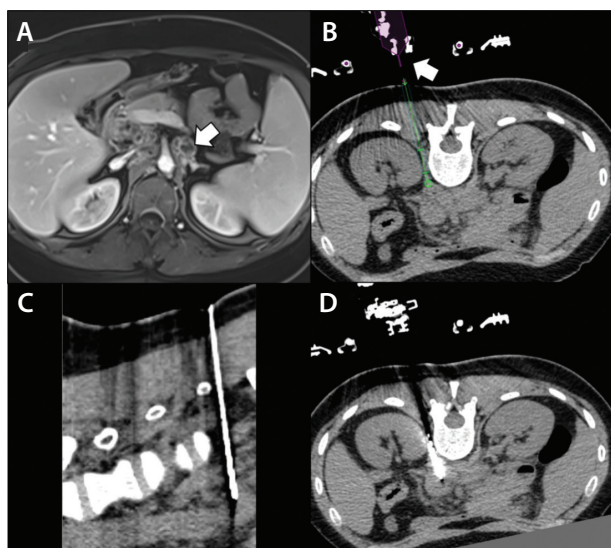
A CT-guided biopsy was performed using the Xact Ace patient-mounted robotic system with steering capabilities. Postcontrast T1-weighted MRI showing retroperitoneal lymph node in a woman in her early 20s (A). Preprocedural planning using robotic software showing the needle path from the entry point to target overlaid on a noncontrast CT image; the arrow is pointing toward the robot (B). Intraprocedural CT during the needle insertion demonstrating the out-of-plane trajectory (C). Intraprocedural CT showing successful needle positioning within the target (D); the biopsy was positive for tuberculosis. Images and case courtesy of Francois H. Cornelis, MD, PhD, Professor of Radiology, Radiology Department, Memorial Sloan-Kettering Cancer Center, Weill Cornell Medical College, New York, New York.
